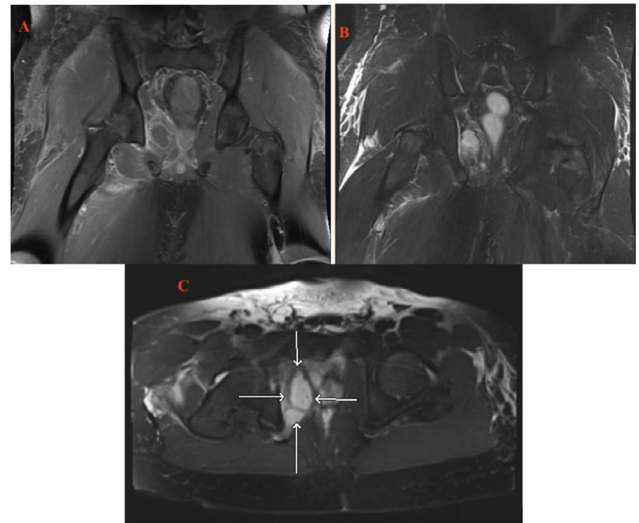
Coronal MRI postgadolinium T1 fat-saturated (A) and STIR (B), and axial T2 fat-saturated (C) showing: abscess in right obturator internus muscle, myositis in right external obturator muscle with involvement of abductor magnus and anteromedial right gluteus minimus, abnormal fluid signal intensity along medial aspect of right pubic bone and pubic symphysis concerning for abscess development and extension into pubic symphysis, and right pubic bone osteomyelitis. MRI, magnetic resonance imaging.
